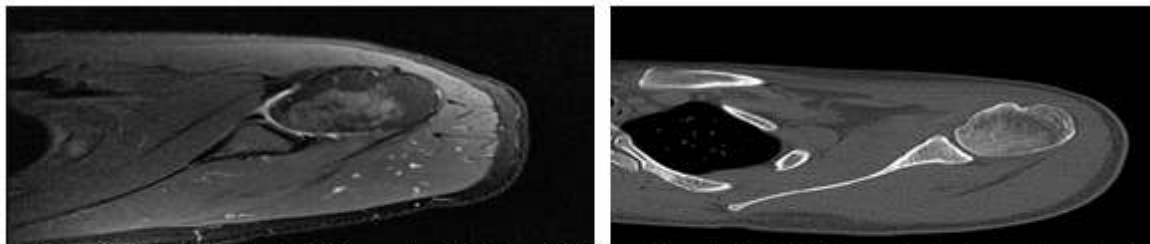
Bony bankart lesion: 26yrs male with history of fall from bike. Axial PD FSE image showing hyperintensity along the anteroanterior quadrant of the labrum. Corresponding axial CT image showing bony defect in the same area.
